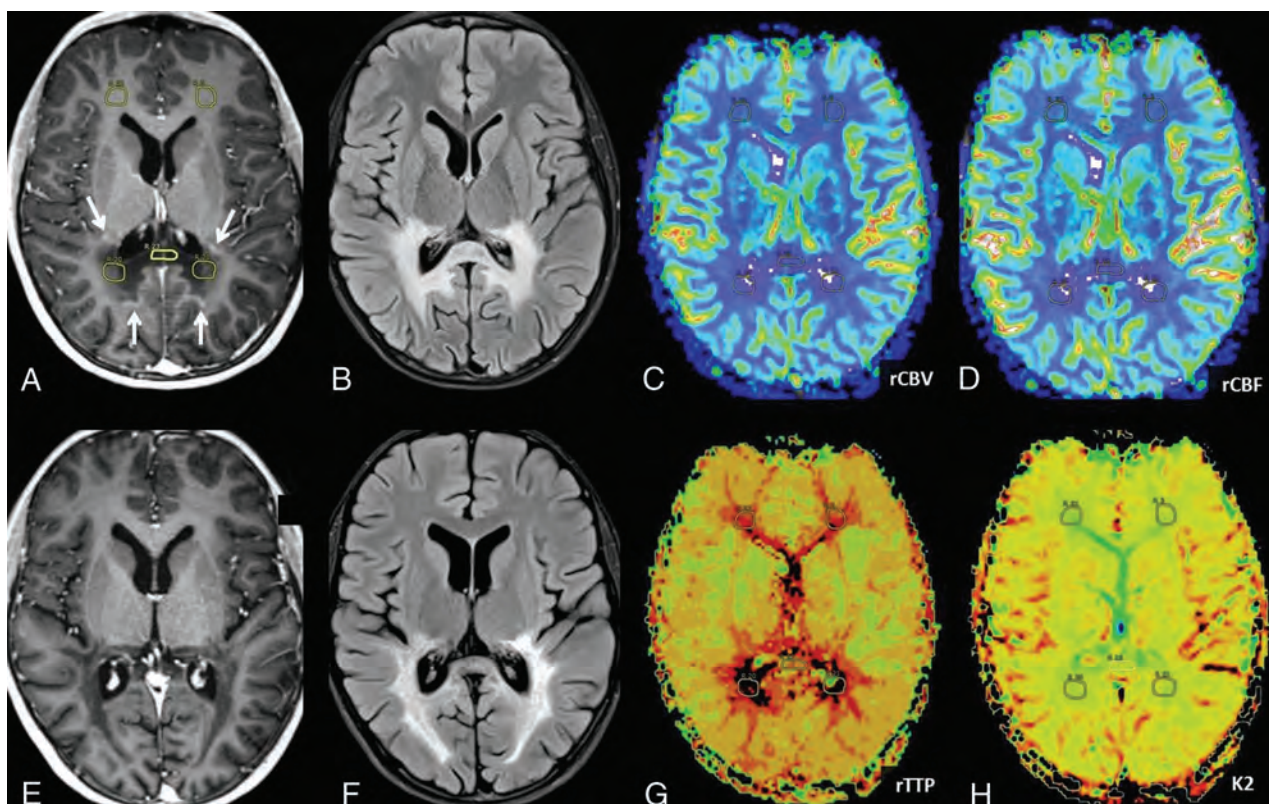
A 15-year-old adolescent boy with ALD. Pre-HSCT postcontrast TIWI (A) demonstrates a LEE (arrows) in the POWM and optic radiations, with edema on noncontrast FLAIR (B). Baseline pre-HSCT ROIs from the NAFWM, POWM, and SCC are depicted on postcontrast TIWI (A) and on the MRP CBV (C), CBF (D), TTP (G), and K2 (H) maps. After HSCT, the 1-year follow-up MR imaging demonstrates resolution of the LEE on postcontrast TIWI (E), with no overt change in the extent of abnormality on FLAIR (F), though mild-moderate cerebral atrophy has ensued, being more prominent within the SCC.
